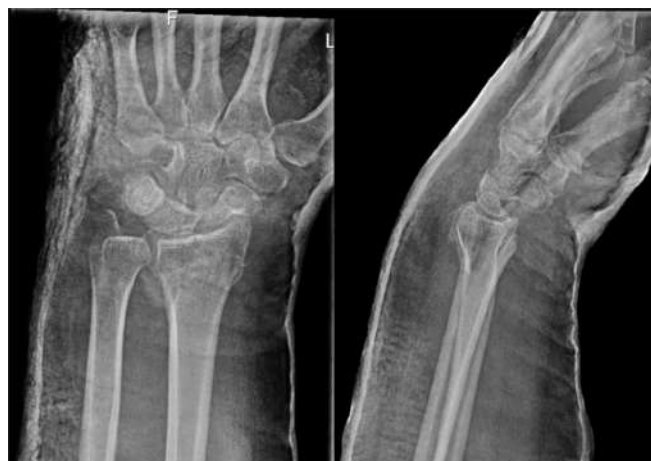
X-ray imaging 2 weeks after repositioning
